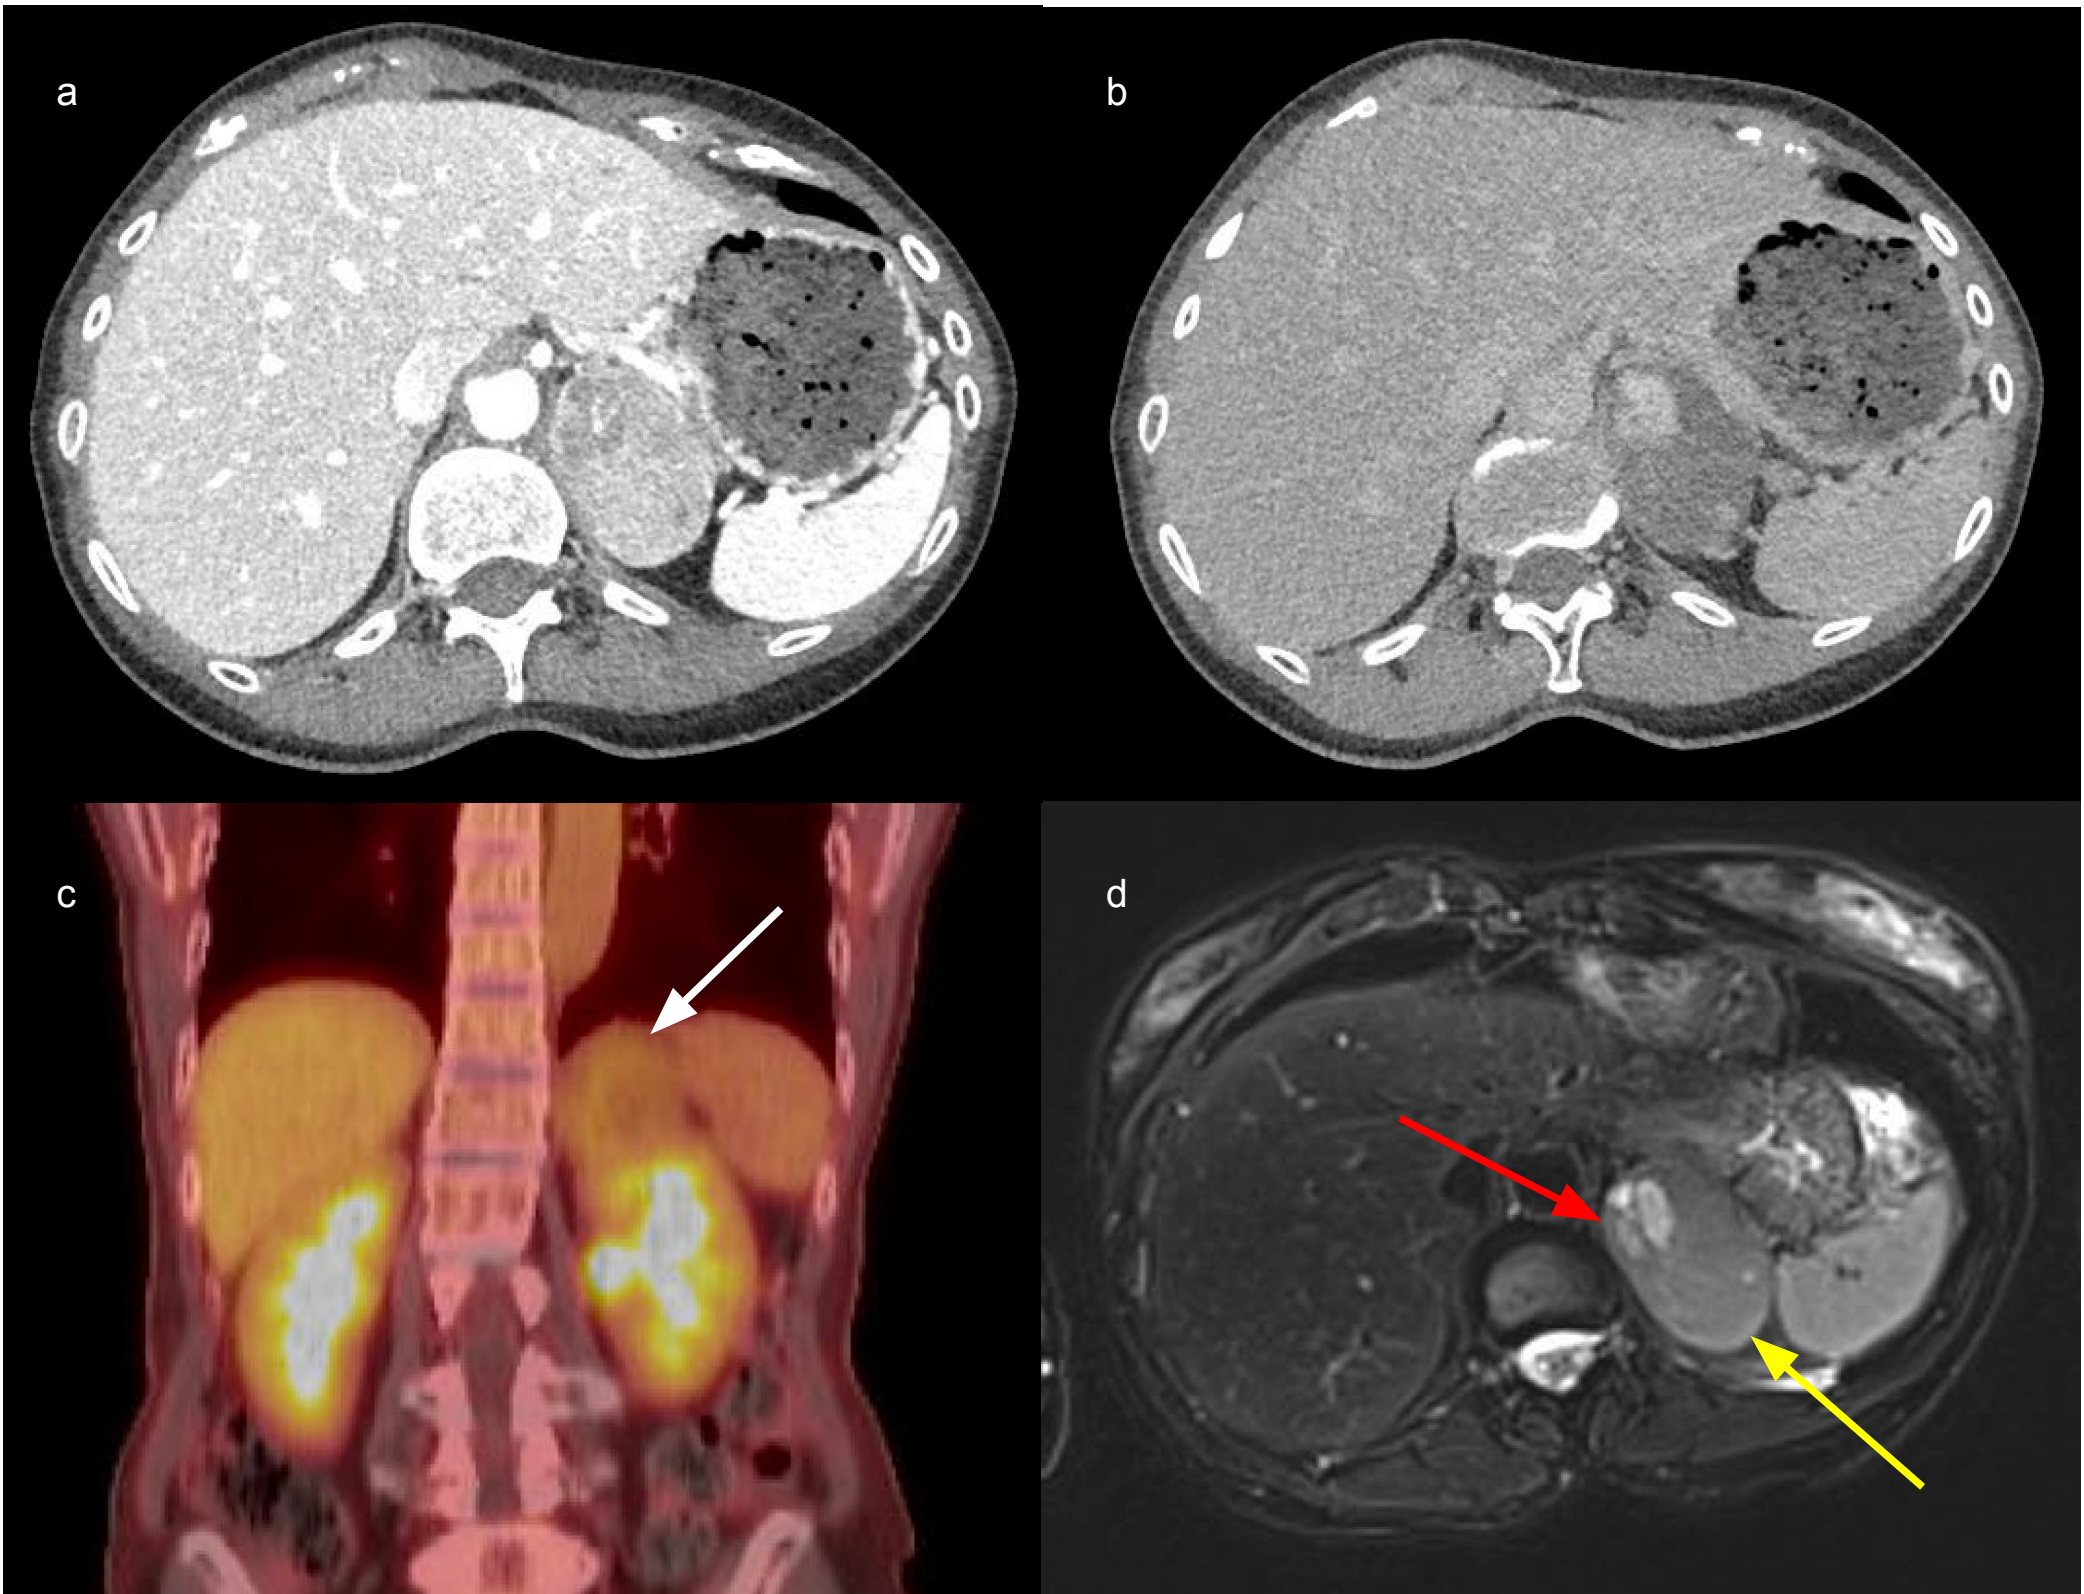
Preoperative imaging of the left adrenal mass. CT axial views in the portal venous (a) and delayed (b) phases showing heterogeneous enhancement and persistent nodular enhancement, respectively. FDG PET coronal view (c) showing mildly hypermetabolic left adrenal activity (SUVmax 2.6, white arrow). MRI without contrast axial view (d) showing medial high T2 signal (red arrow) with and lateral intralesional fat (yellow arrow).
